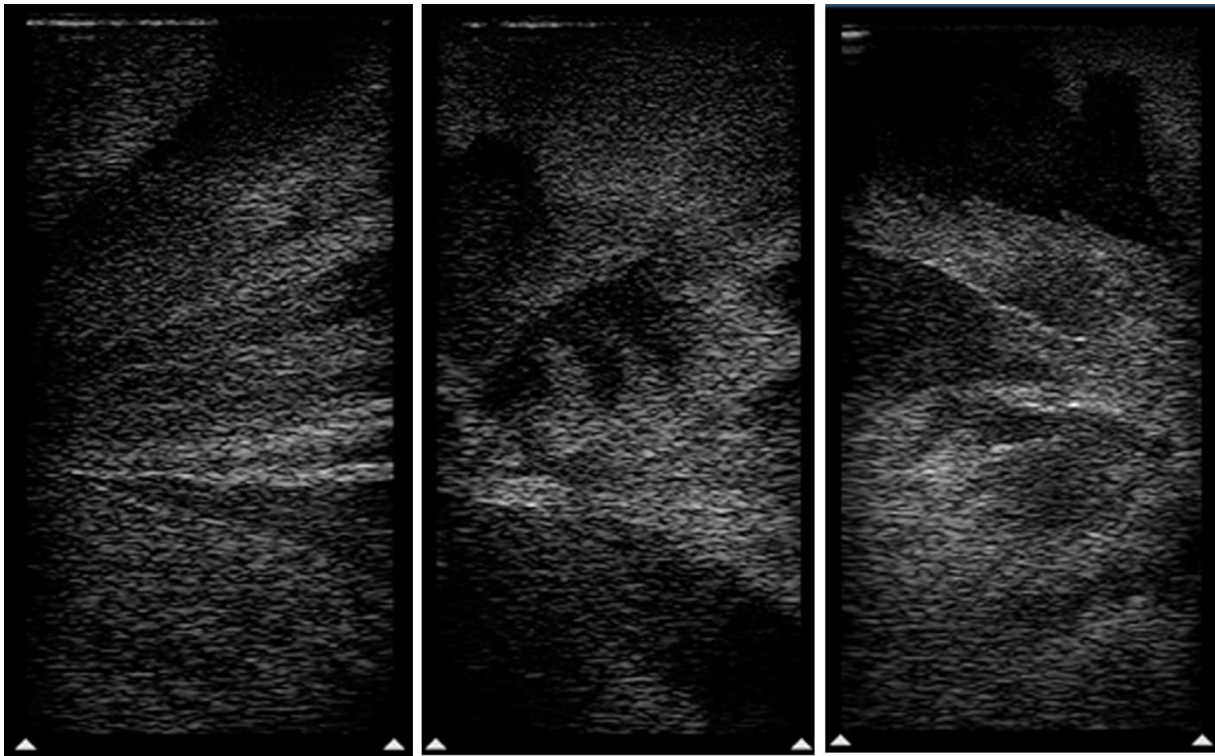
Ultrasound visualization PVA 7% 3FT : Images obtained with 5 cm penetration depth
